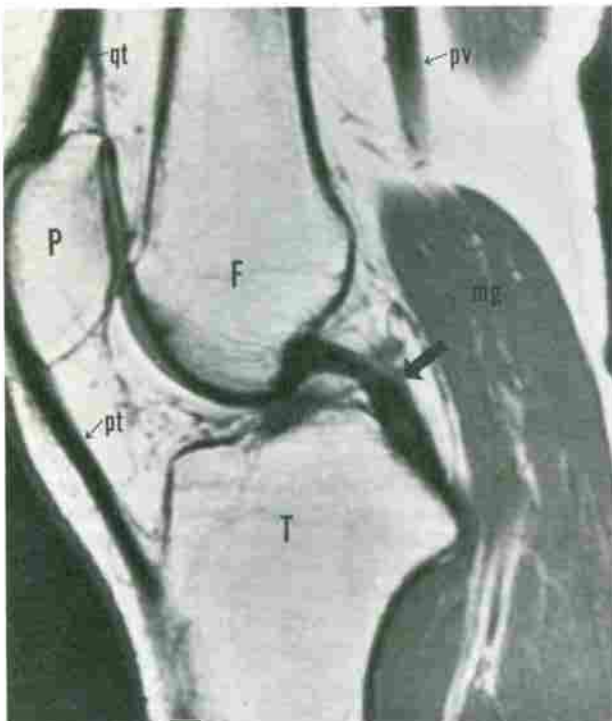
Normal posterior cruciate ligament (PCL). Sagittal T1-weighted (TR/TE, 800/20) image through the intercondylar notch shows the normal course and configuration of the PCL, which extends from the posterior aspect of the intercondylar eminence, well below the joint line, to the medial femoral condyle (arrow). The normal PCL has diffuse low-signal intensity on all pulse sequences. Note the normal homogeneous high signal intensity of fatty marrow of the different osseous structures. F, femur; T, tibia; P, patella; pt, patellar tendon; qt, quadriceps tendon; mg, medial head of gastrocnemius muscle; pv, popliteal vessel.
